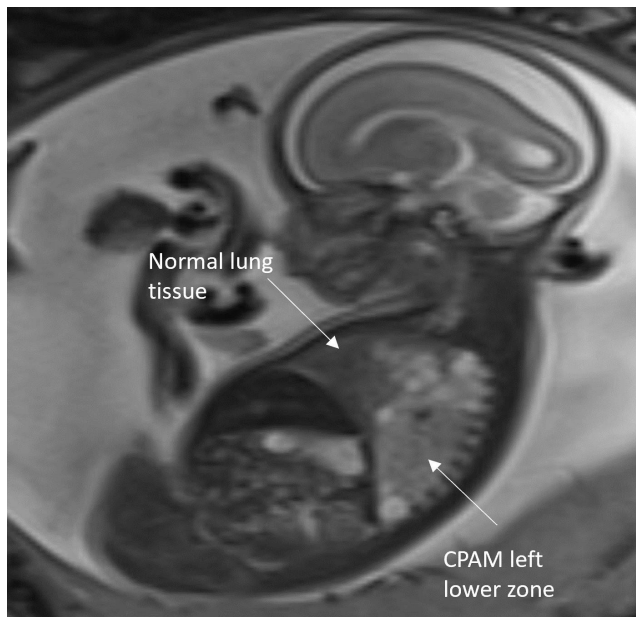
T2 HASTE STIR Sagittal MRI image of left lower zone CPAM in 22+4 week fetus
